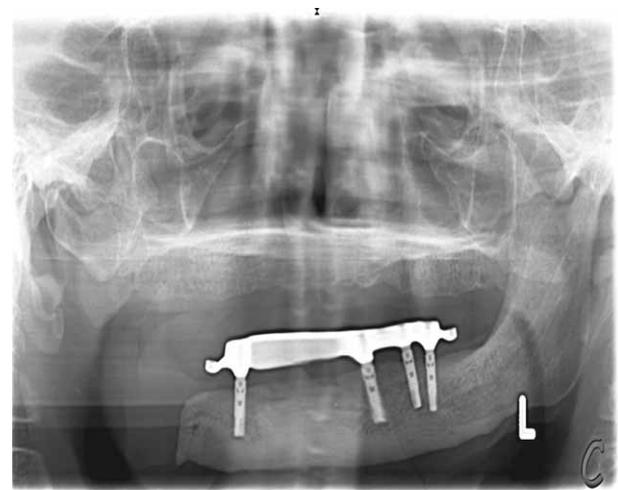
Radiographic evaluation after 1 year.
